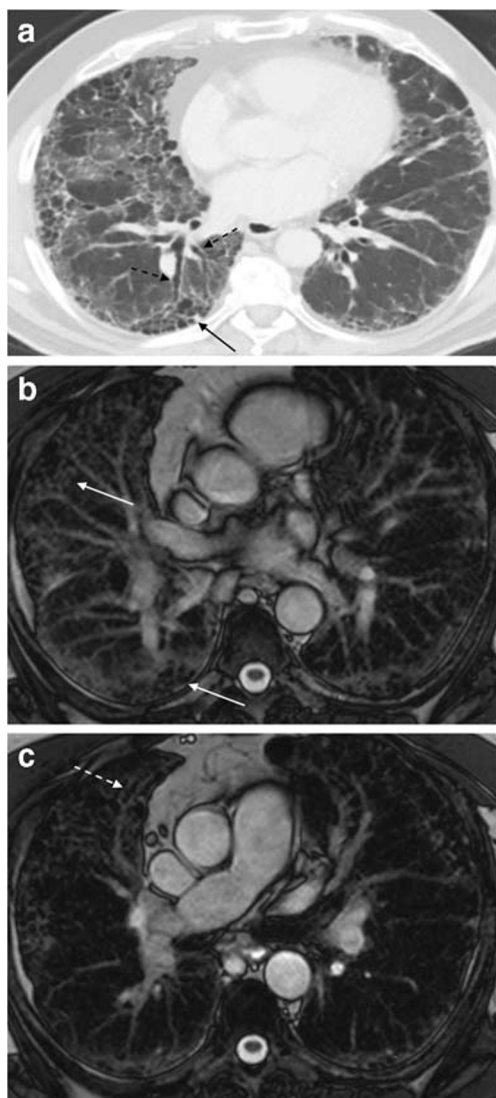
Sixty-year-old man with usual interstitial pneumonia prior to lung transplant. a Non-contrast axial CT image demonstrates typical features of UIP, architectural distortion, traction bronchiectasis (black dashed arrows), and honeycombing (black arrow). b, c TRUFISP images show linear and nodular interstitial high T2 signal with honeycombing (white arrows) and traction bronchiectasis (dashed white arrow)
